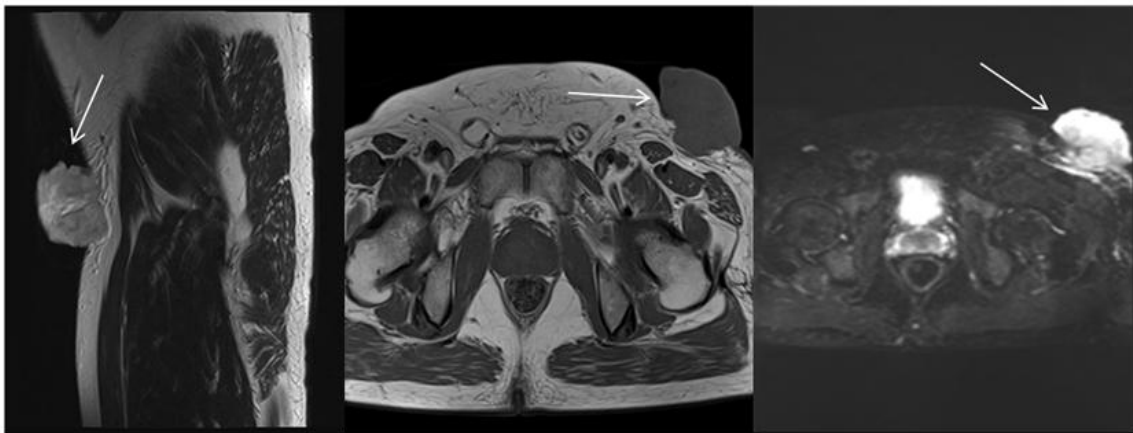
An abnormal signal mass approximately 5.1 cm * 7.1 cm is seen within the subcutaneous soft tissues in the area near the inguinal region at the root of the left thigh. It shows long T1 and long T2 signal shadows. On DWI, it presents a high signal, and on the ADC map, it shows a slightly high signal. The outline of the lesion is relatively smooth, the boundary is clear, and it protrudes outside the contour of the thigh. Flaky and flocculent exudative shadows are observed within the subcutaneous fat layer at the root of the left thigh. The white arrow points to the location of the mass.
